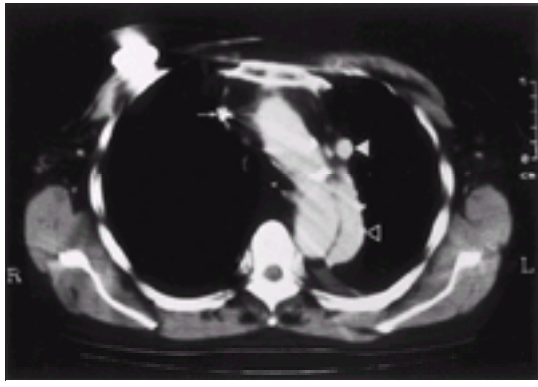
Contrast enhanced CT at the level of the aortic arch shows a left superior vena cava (white arrowhead) and a right superior vena cava with a pacemaker wire *in situ* (arrow). The dilated hemiazygos vein (white lined arrowhead) is due to hemiazygos continuation of the inferior vena cava.
